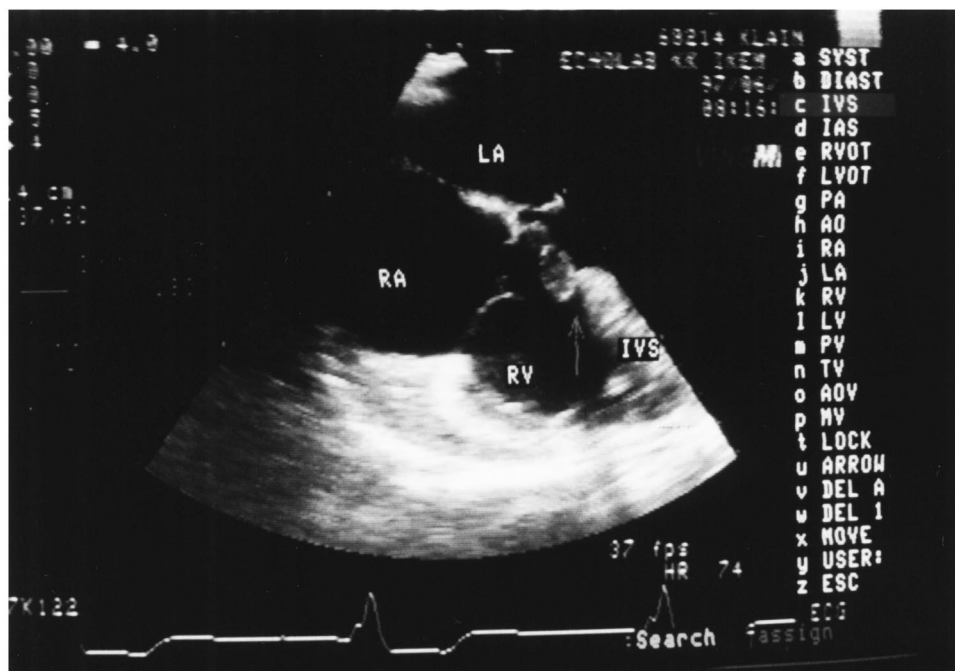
Transesophageal echocardiogram of a post-traumatic ventricular septal defect. Arrow indicates the site of defect. RA, right atrium; RV, right ventricle; LA, left atrium; IVS, interventricular septum.
